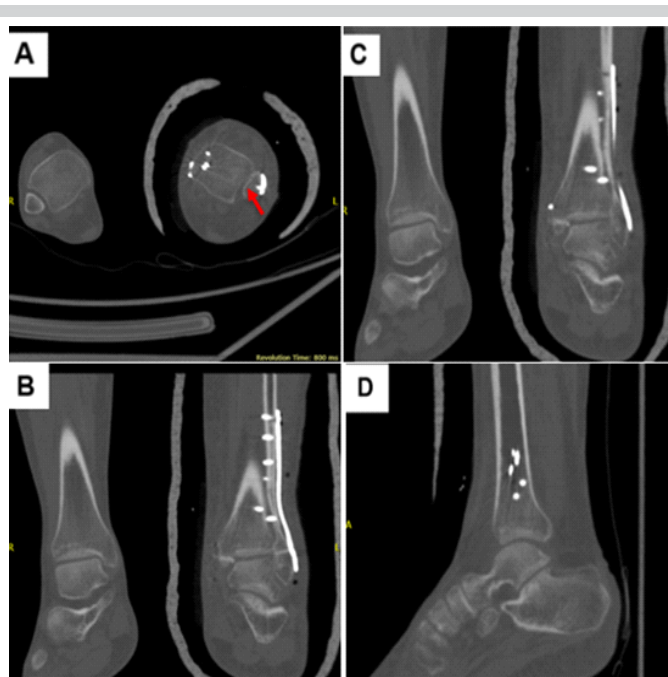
Follow-up computed tomography scan showing anterior subluxation (red arrow) of the syndesmosis. Axial (a), coronal (b and c), and sagittal (d) views.
